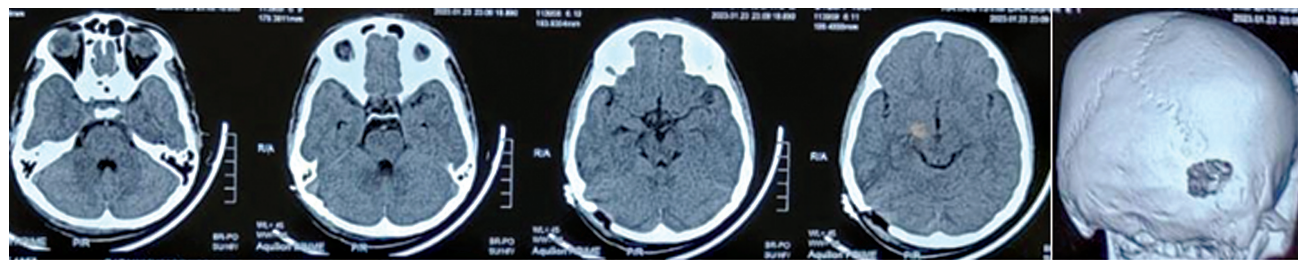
Postoperative computed tomography (CT) scan with 3D reconstruction.
